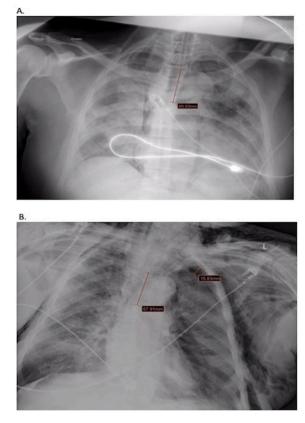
Chest X-ray images intubated COVID-19 patients with barotrauma. A. Pneumomediastinum B. Pneumothorax and extensive subcutaneous emphysema
